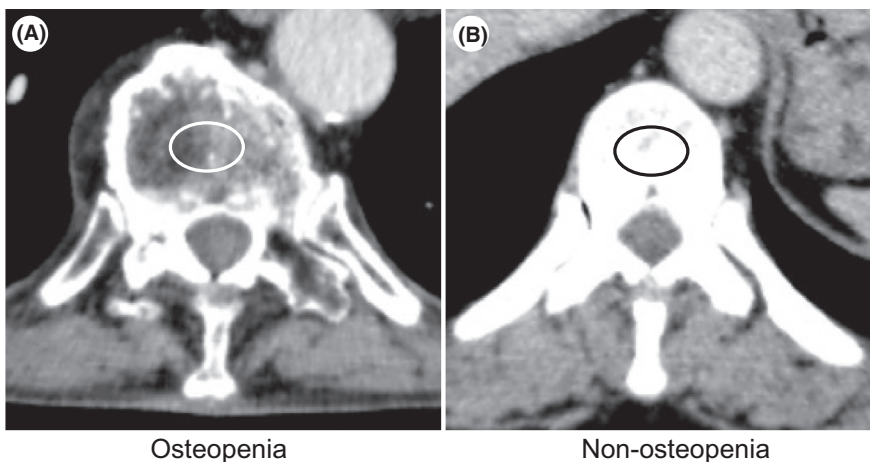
We calculated the average pixel density of the trabecular bone to analyze bone mineral density by placing elliptical regions of interest in the mid-vertebral core of the 11th thoracic vertebra on preoperative enhanced CT. A: Osteopenia and B: nonosteopenia. CT, computed tomography
